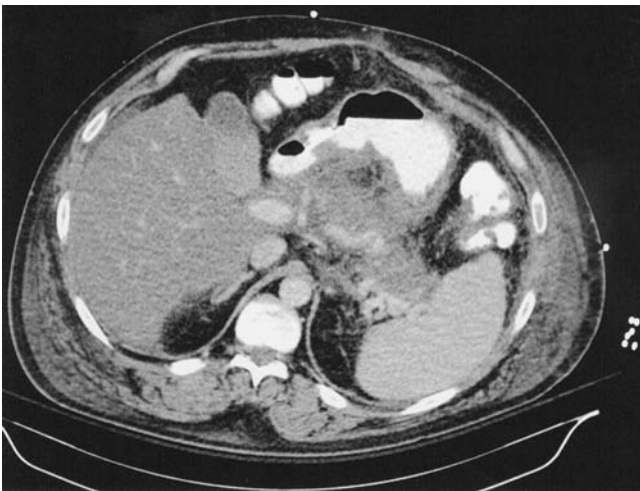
Contrast-enhanced abdominal CT scan in the same 47-year-old man with a second episode of acute pancreatitis. Scan shows stranding of peripancreatic fat, consistent with acute pancreatitis. Most notable is the near-complete absence of pancreatic enhancement, diagnostic of pancreatic necrosis. (Reproduced with permission from Clancy TE, Benoit EP, Ashley SW. Current management of acute pancreatitis. *J Gastrointest Surg.* 2005;Mar;9(3):440–452.)
